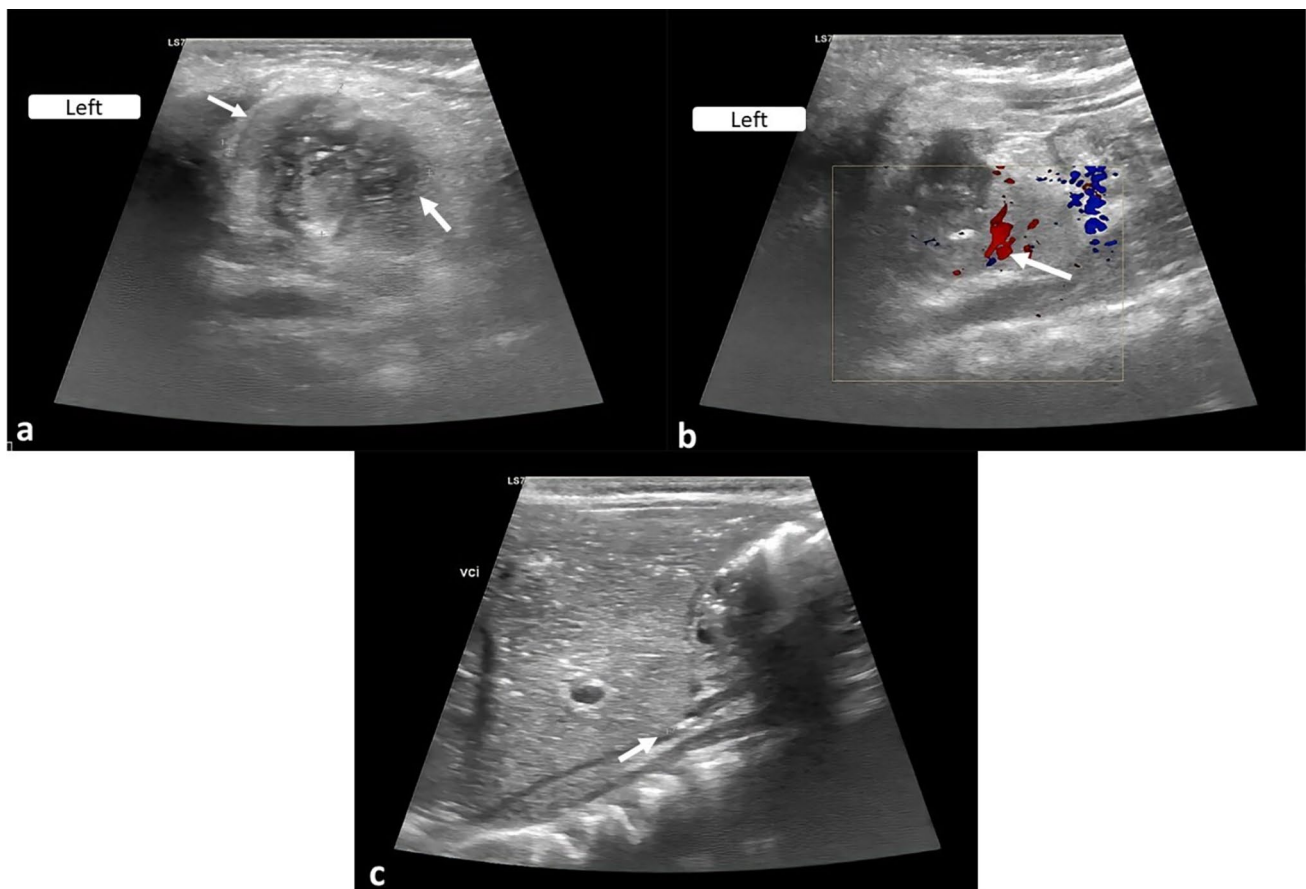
a The left kidney has a calcified heterogeneous region (white arrows) that is not vascularized on Doppler imaging, and (b) Doppler ultrasound at the left lower pole of the kidney shows arterial flow
